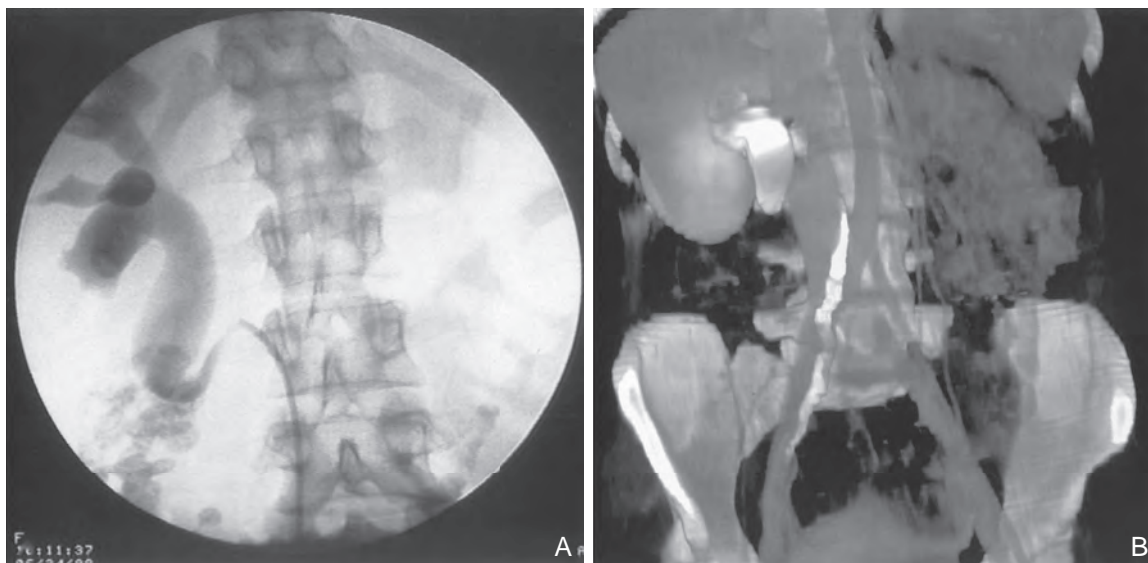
A, Retrograde pyelography in a patient with right-sided hydronephrosis. This study reveals a typical S-shaped deformity secondary to the ureter coursing laterally to medially posterior to the inferior vena cava. B, Three-dimensional spiral computed tomography demonstrates the presence of a retrocaval ureter.
